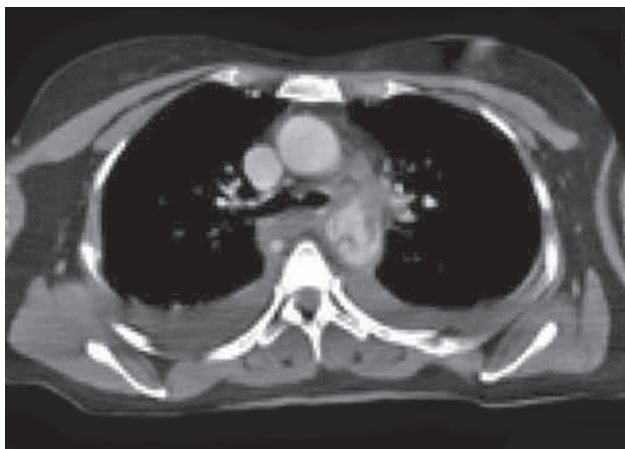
Preoperative computed tomography (axial plane).
